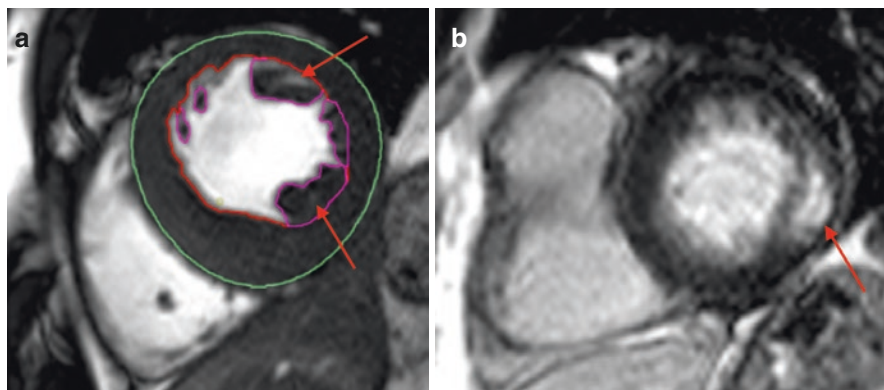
(a) Cardiac Magnetic Resonance Imaging showing concentric Left ventricular hypertrophy with prominence of papillary muscles (arrows). (b) Gadolinium enhancement demonstrating scar tissue typically in the inferolateral segments (arrow). (Images courtesy of Dr. R Kozor)
